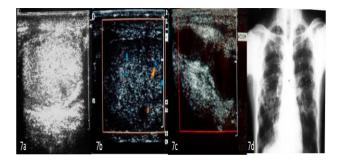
Testicular tuberculosis; (a) Right testis shows heterogeneous appearance with multiple hypodence area; (b) Doppler of the same patient shows multiple spotty signals. (c)The spermatic cord was thickened,hypoechoic and showed a beaded appearance. (d) Chest X ray shows fibrotic and infiltrative lesions in right upper and lower zone.
